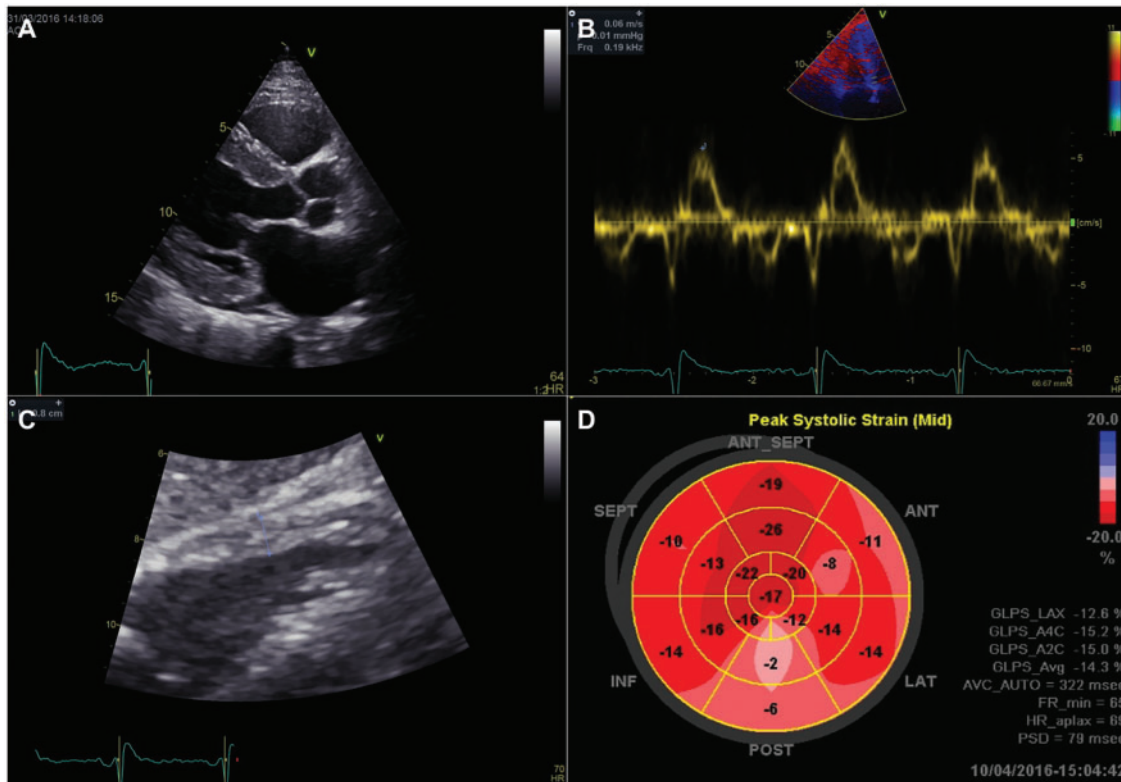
Echocardiography. (A) Concentric left ventricular hypertrophy in parasternal long axis view. (B) Low septal tissue velocities. (C) Right ventricular hypertrophy. (D) Low longitudinal strain with inferior wall of the left ventricle.
